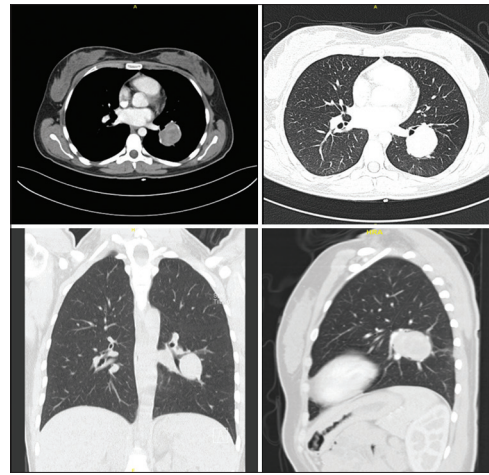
Contrast-enhanced CT of the chest showing a 4.0 cm x 3.3 cm well-defined, rounded, and heterogeneous mass of the left lower lobe. Note the internal hyperdensity and the absence of intrabronchial invasion
